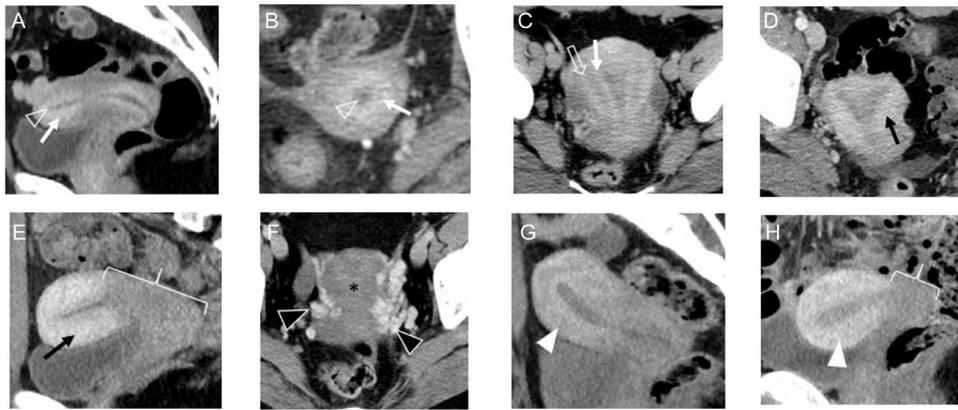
Wide range of normal uterine enhancement patterns are observed on contrast enhanced CT. (a) and (b) sagittal and axial CT images of different patients show normal thin (A) and thick (B) subendometrial enhancement (arrow). Also note the variable thickening of the normal hypoattenuating endometrial tissue (open arrowheads), not to be confused with fluid in the endometrial canal. (C) Axial CT image shows a normal retroverted uterus with both subendometrial enhancement (arrow) and outer myometrial (open arrow) enhancement. (D) and (E) axial and sagittal CT images of a normal uterus with diffuse myometrial enhancement (black arrows), (F) axial CT image shows minimal diffuse enhancement (asterisk) and dilated pelvic varices (black arrowheads). (G) and (H) Sagittal CT images of different patients show normal patchy heterogeneous enhancement of the myometrium (arrowheads). Note the relative hypoenhancement of the cervix compared to the uterus (brackets) on e and h.
